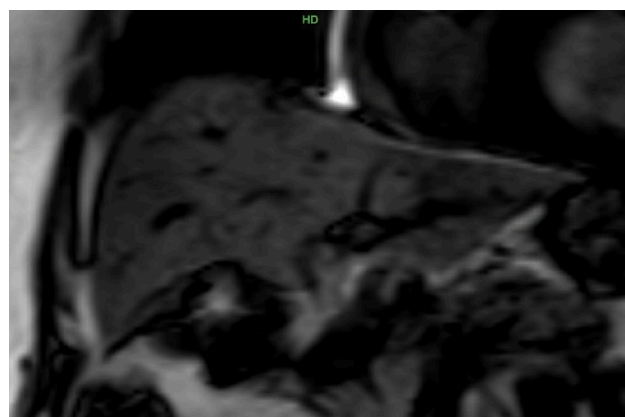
MRI Abdomen with contrast MRCP revealing hepatic steatosis and multiple subcentimeter hepatic cysts.
